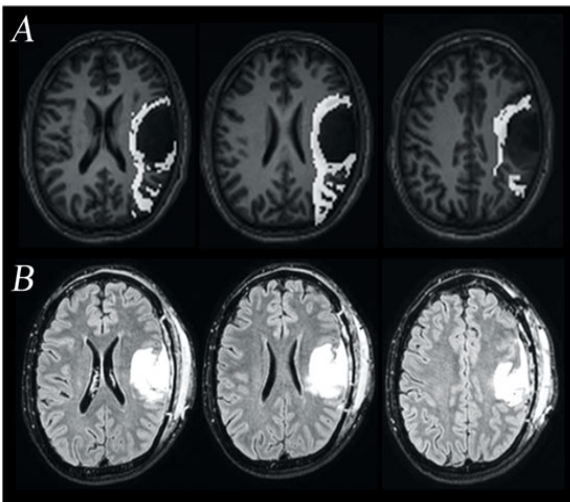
(A, B). SLF reconstruction in case of left frontoparietal low-grade oligodendroglioma. The SLF (white bundle) was reconstructed by DTI-FT and superimposed on morphologic T1-weighted images; the tract was dislocated and slightly infiltrated by the tumor mass (A); the tract was identified intraoperatively by DES (onset of phonemic paraphasia) in the same position where it was located by DTI-FT, as shown by the postoperative postcontrast T1-weighted images, where the margin of resection was coincident with the location of the SLF (B). Part of the tract was removed at the time of surgery because found not functional
